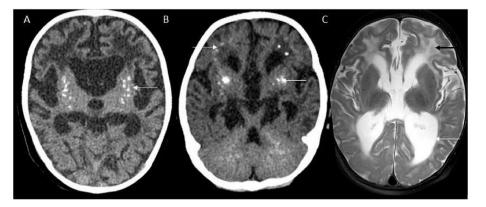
Aicardi Goutières Syndrome: Axial CT (A, B) shows discrete punctate pattern of calcification in the putamen and periventricular white matter. Coalescent punctate calcification of the cerebellar white matter is also seen. T2 axial image(C) shows diffuse white matter hyperintensity with volume loss and associated lateral ventricular enlargement.
